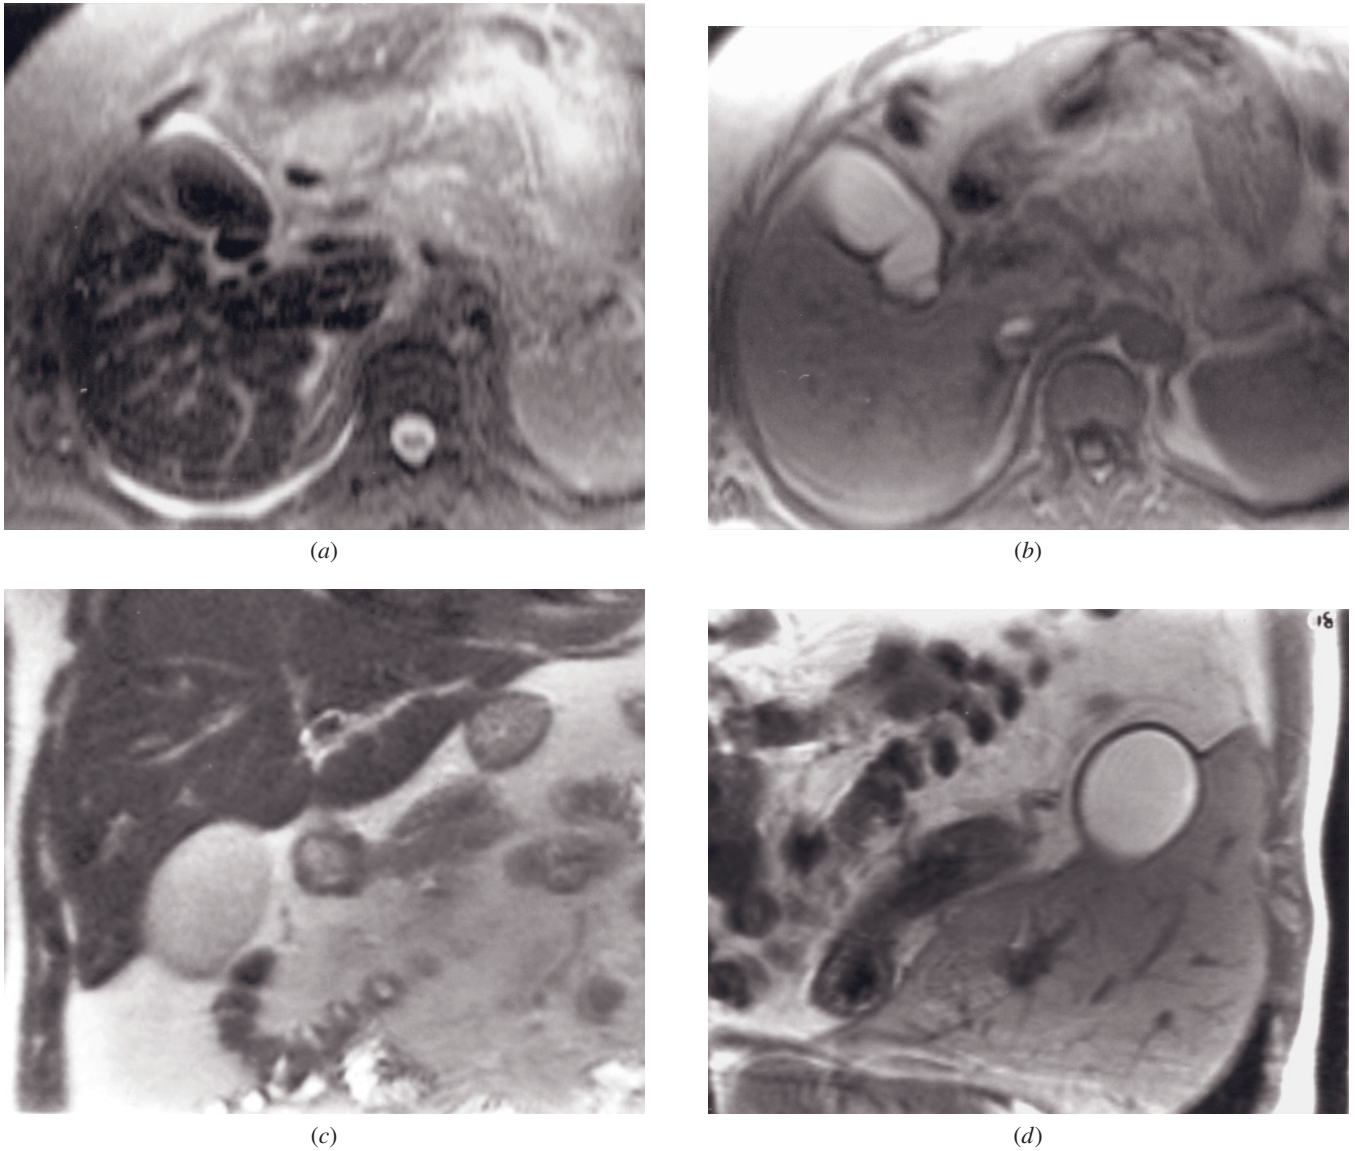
Abnormal signal of bile. T2-weighted fat-suppressed spin-echo (*a*) and T1-weighted GE (*b*) images in a patient with primary biliary cirrhosis. The bile in the gallbladder is highly concentrated, resulting in low signal on the T2-weighted image (*a*) and high signal on the T1-weighted image (*b*). A small pleural effusion is present in the right posterior pleural recess showing high signal on the T2-weighted image (*a*).
